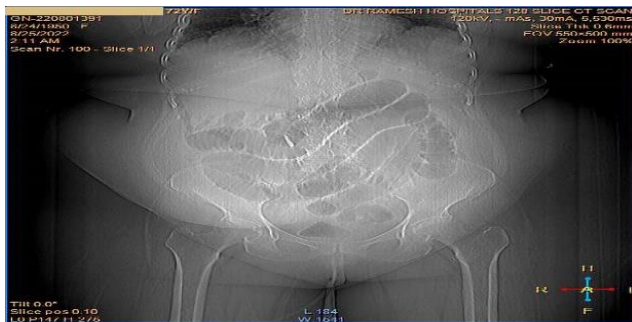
Erect CT showing air fluid levels.
